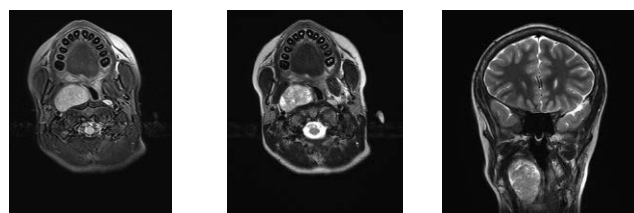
Tumour on MRI scan
